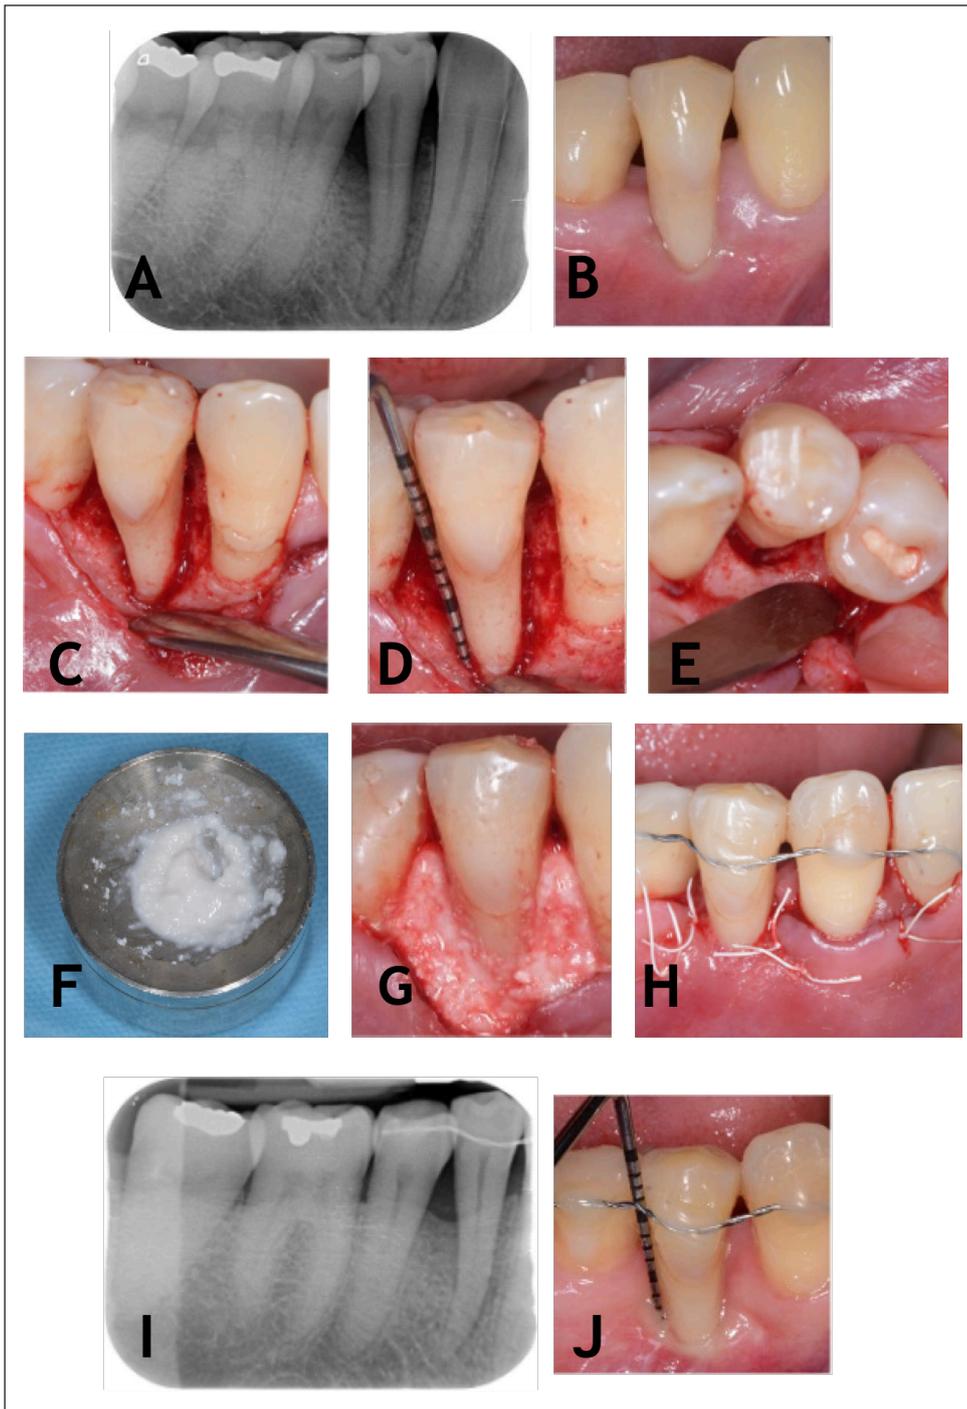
Case 3, circumferential defect associated with mandibular right first premolar. (A) Preoperative radiograph. (B) Preoperative clinical image. (C-E) Flap elevation and intra-surgical defect assessment. (F) Autologous micrografts endorsed on the scaffold to form a biocomplex. (G) Biocomplex entirely filling the intrabony component of the defect. (H) Primary closure by means of horizontal mattress and simple interrupted sutures. (I) Periapical radiograph at 6 months post-operatively showing the complete closure of the defect. (J) Six-month post-operative periodontal probing depth.
